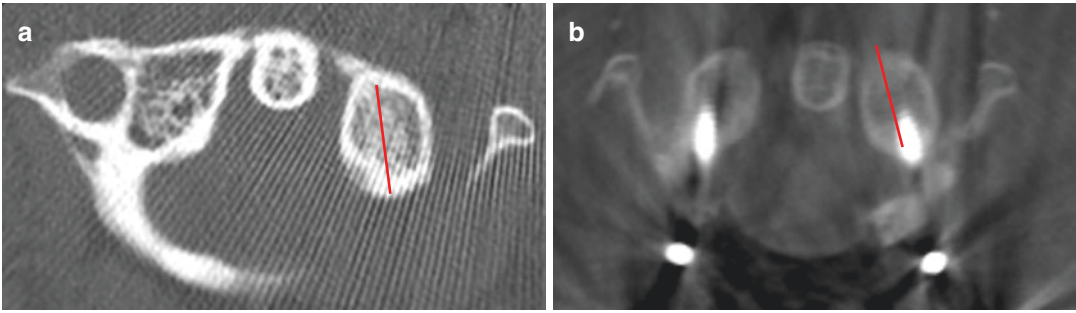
Preoperative (a) and postoperative (b) CT of a patient undergoing C1 instrumentation. Note the red line indicating the preferred trajectory from the posterior-most aspect of the left lateral mass along the long axis
